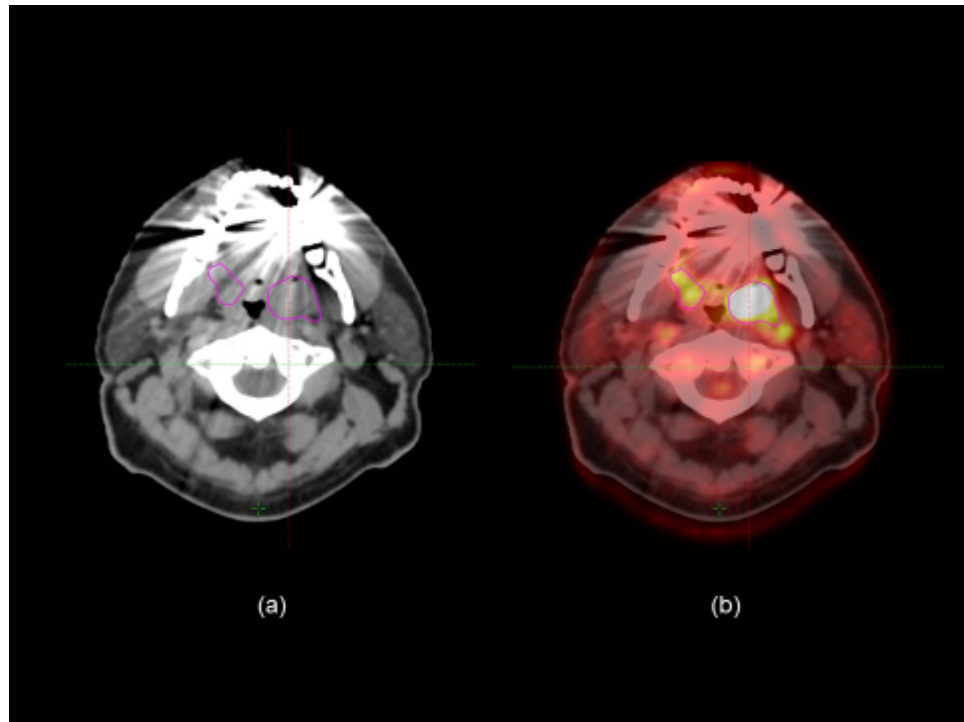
Dental artefacts can obscure the primary tumour in the oropharyngeal region on contrast enhanced CT (a). The functional information from PET/CT can easily identify viable tumour (magenta) if MRI is not available.
